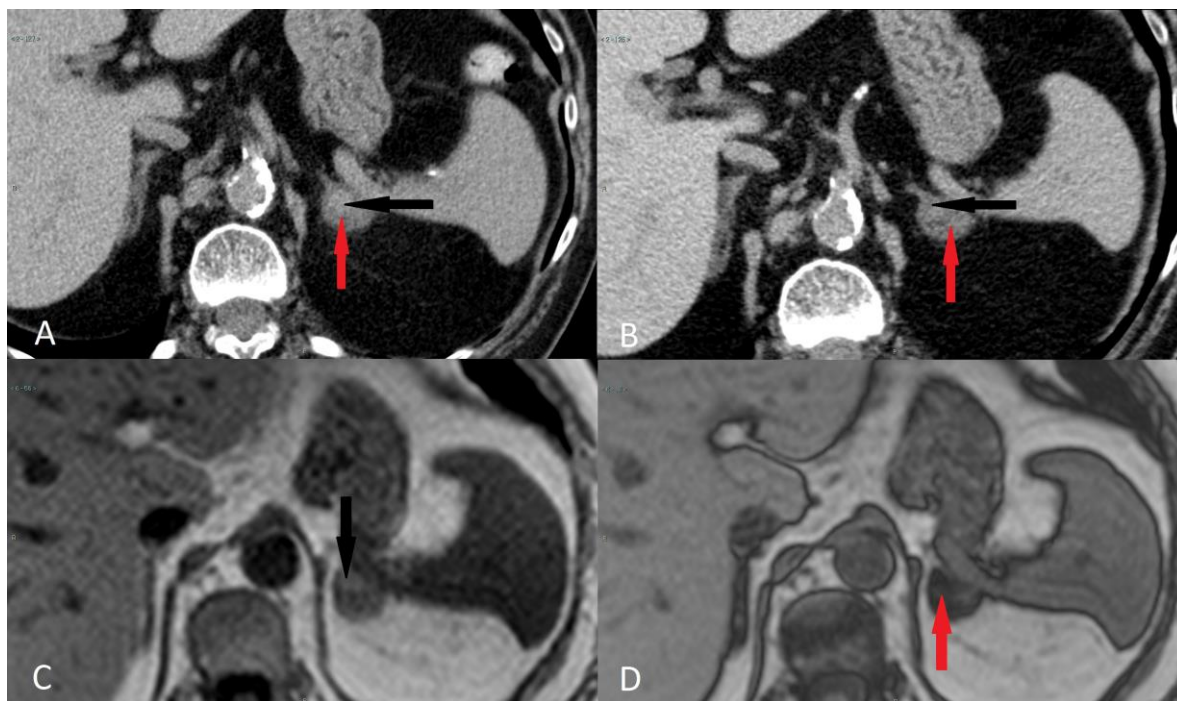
A 76-year-old woman with an adenoma-hemangioma adrenal collision tumor. 2016 Computed Tomography (A). 2015 Computed Tomography (B). 2013 Magnetic Resonance Imaging (C-D).
